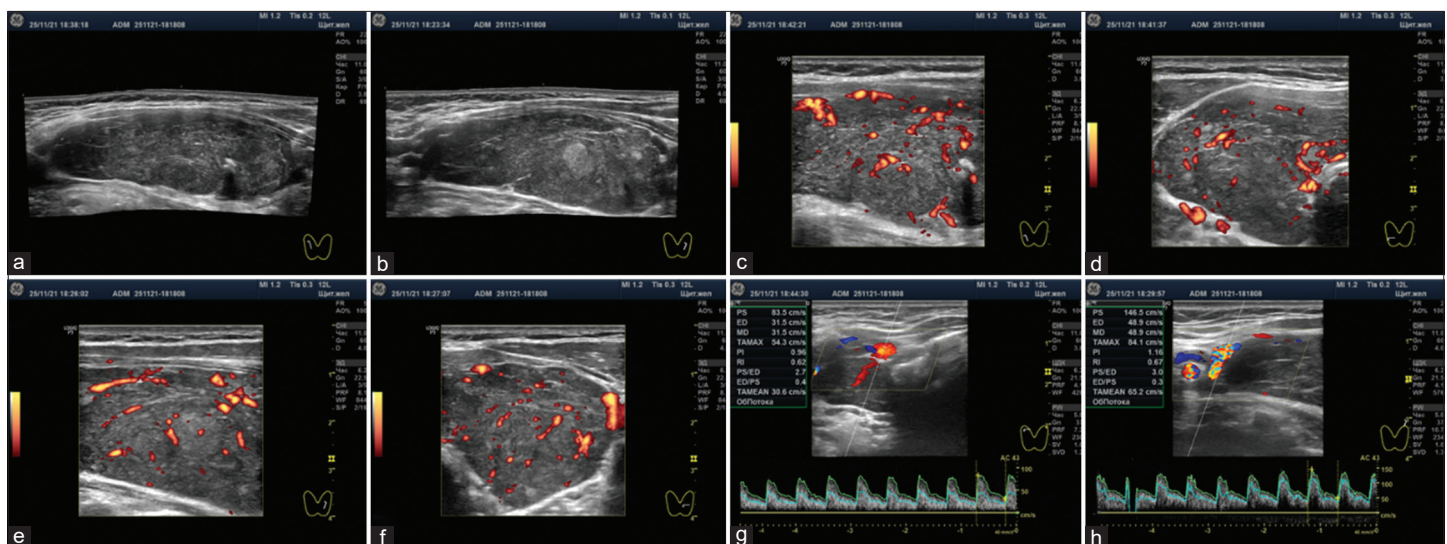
Ultrasound data. (a and b) Panoramic images of the right and left lobes of the thyroid gland in the longitudinal projection; (c and d) Images of the right lobe of the thyroid gland in transverse and longitudinal projections in the Doppler energy mode; (e and f) Images of the left lobe of the thyroid gland in transverse and longitudinal projections in the Doppler energy mode; and (g and h) Peak systolic blood velocity of the superior thyroid arteries on the right and left
